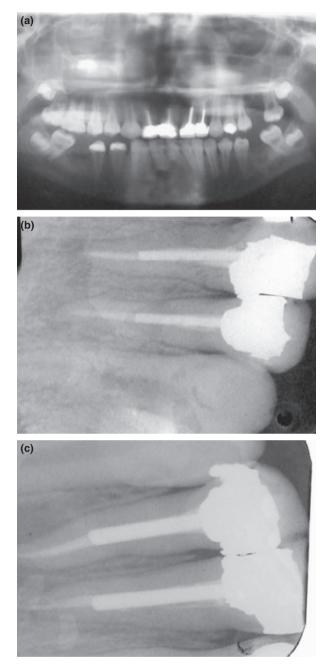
(a) The radiographic view of the final restorations. (b) The radiographic view of the final restorations. (c) The radiographic view of the final restorations.
